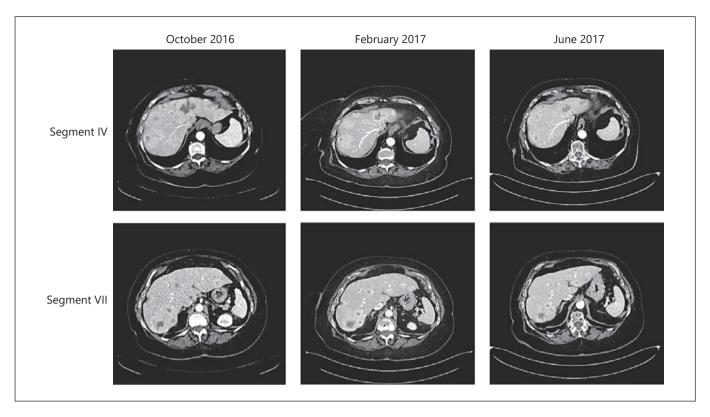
CT scans of liver lesions in IV and VII segments.
